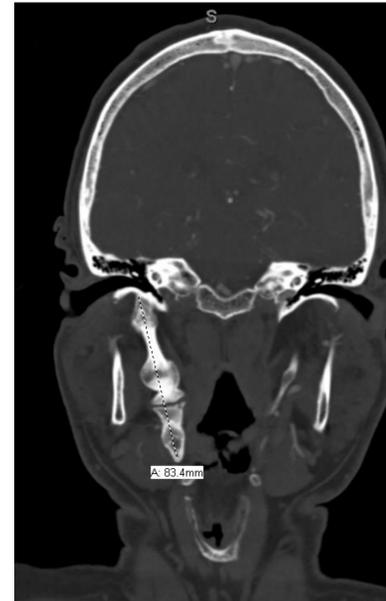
Right styloid process on CT imaging at initial presentation
